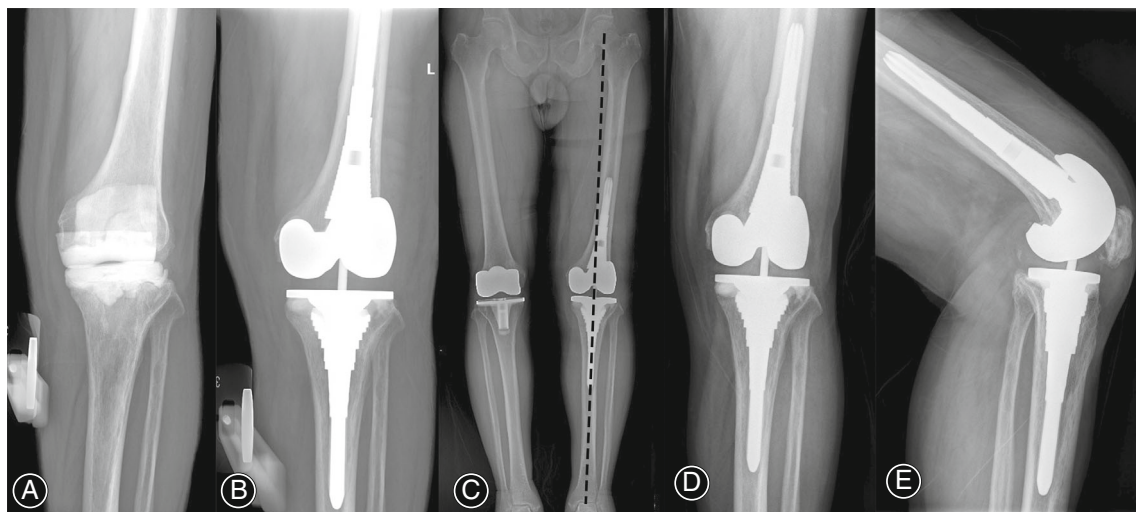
Radiographs of a 71-year-old male who underwent two-stage revision TKA with tibial and femoral metaphyseal sleeves for infection. Preoperative (a) and postoperative (b) radiographs from the AP view; The postoperative full-length X-ray (c) showed satisfactory alignment. After a follow-up of 5.1 years, the AP (d) and lateral (e) radiographs demonstrated stable fixation
